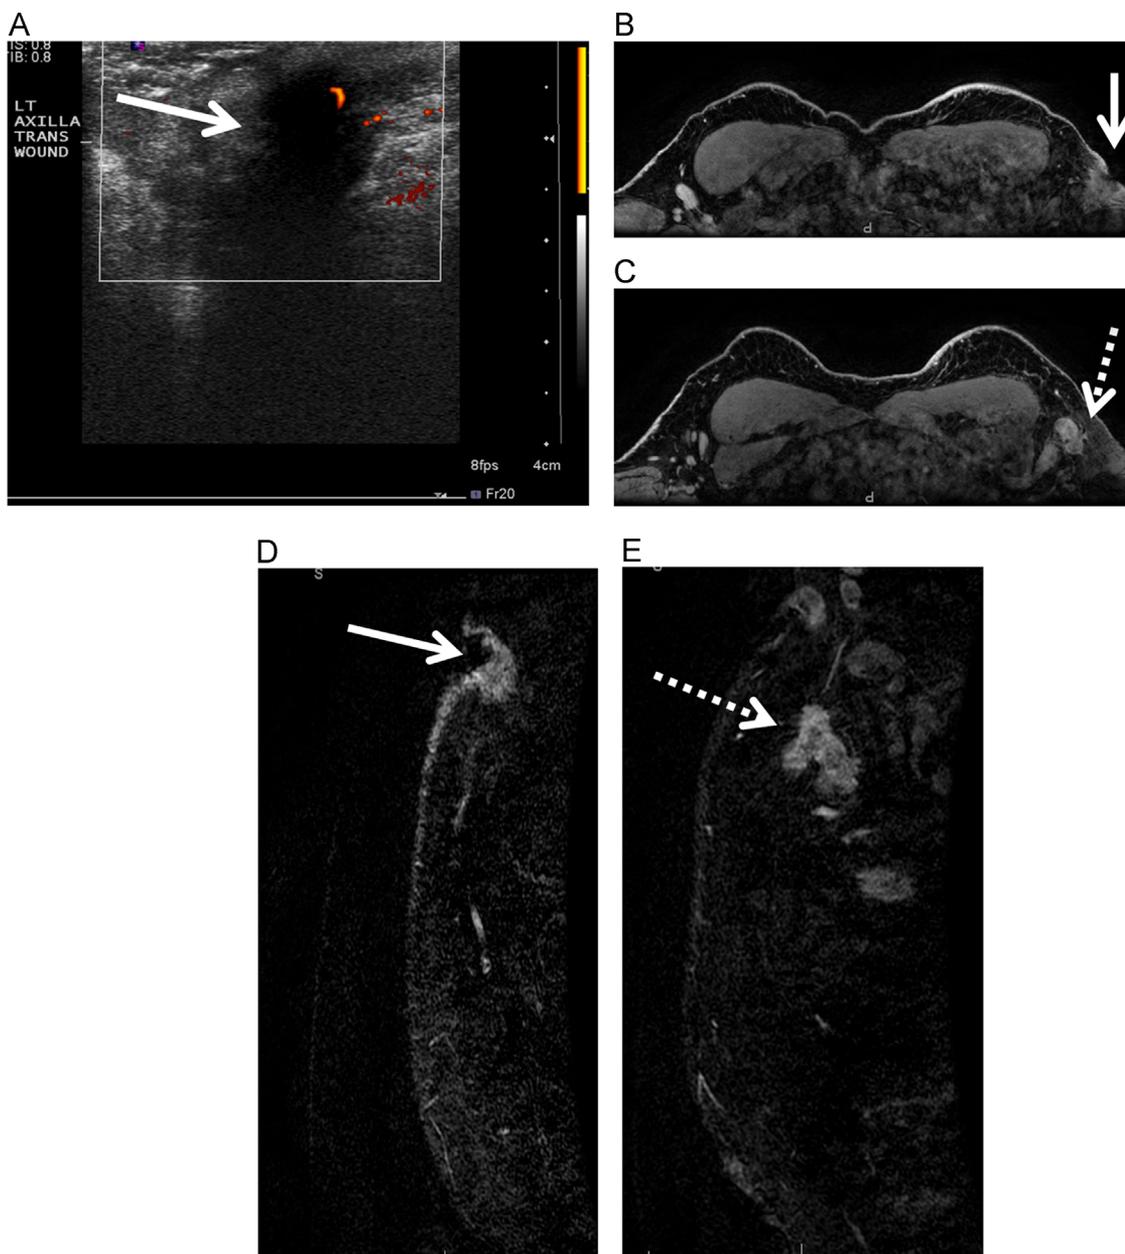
A 55-year-old male patient with a history of moderately differentiated adenocarcinoma involving the dermis and the epidermis with pagetoid extension, presented with an open wound. US with power Doppler imaging (A) in the area of the open wound in the left axilla shows a suspicious irregular, hypoechoic mass with indistinct margins (arrow). Axial postcontrast T1-weighted images with fat suppression (B and C) demonstrate a corresponding irregular mass with spiculated margins and heterogeneous enhancement just deep to the wound (solid arrow) (B). Also noted was extensive left axillary lymphadenopathy and nodal masses with indistinct margins, due to extranodal extension of disease (dotted arrow) (C). Sagittal T1-weighted postcontrast MRI with fat suppression also demonstrates an irregular mass just deep to the wound (solid arrow) (D) as well as extensive left axillary lymphadenopathy and nodal masses (dotted arrow) (E). (Color version of the figure available online.)
